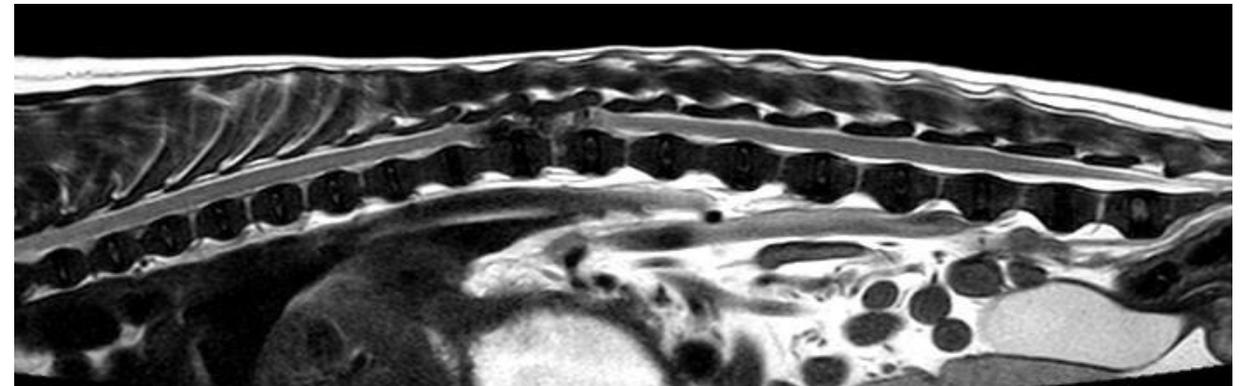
Thoracolumbar T2-weighted MRI: severe HNP type I at T12-T13 with spinal cord compression. Note the black discs at most intervertebral disc locations (chondrodystrophy).
